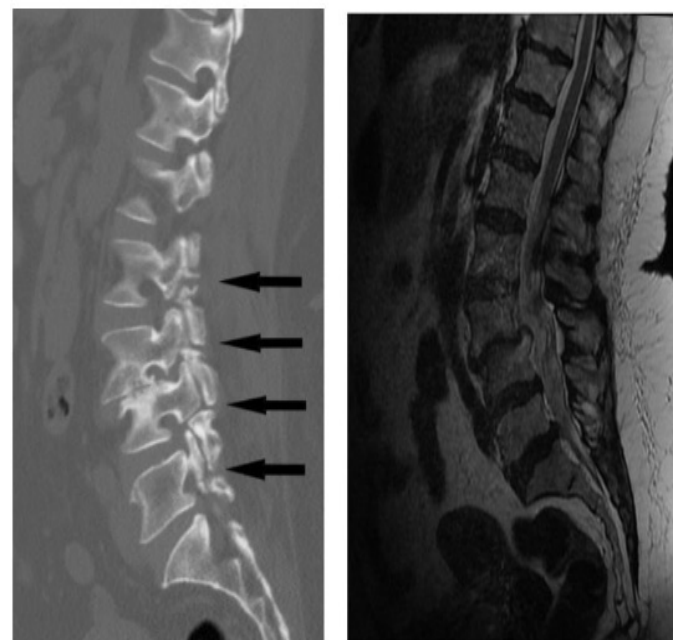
Preop sagittal CT- preop sagittal T2 MRI image. L2-3/L3-4/L4-5/L5-S1 pars fracture, L3-4 listhesis and stenosis are observed.
